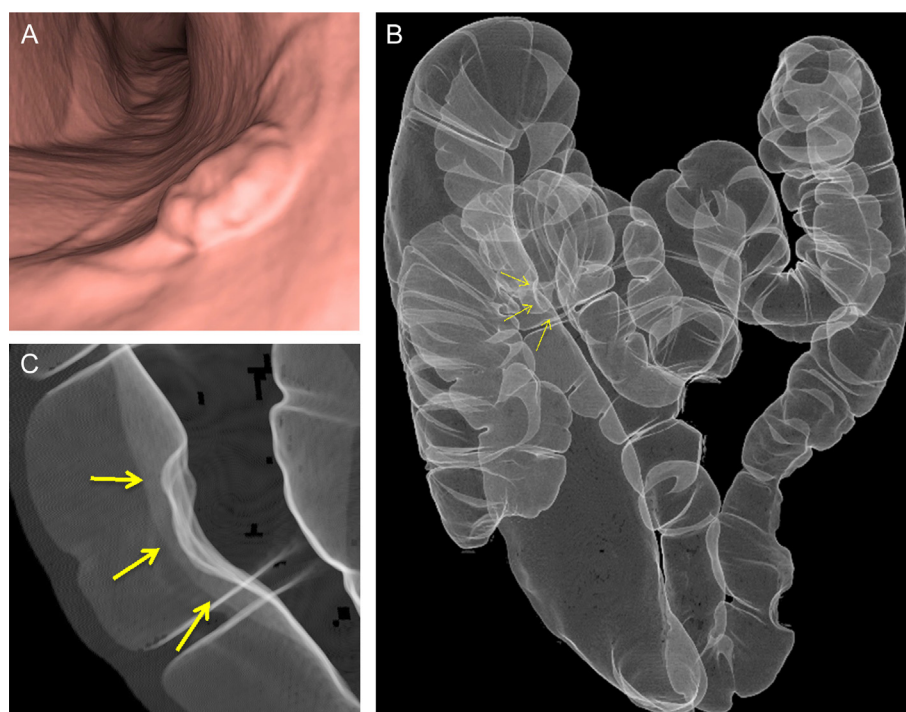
CTC images of a patient with a long sigmoid colon. Both three-dimensional endoluminal surface-shaded volume rendering images and DCBE-like images detected sigmoid colon cancer (20 mm, type 2, pT2). (A) A three-dimensional endoluminal surface-shaded volume rendering image. (B) A DCBE-like view of the entire colon; the location of the cancer is indicated by the yellow arrow. (C) A magnified DCBE-like view of the sigmoid colon cancer. CTC = computed tomographic colonography; DCBE = double-contrast barium enema.
